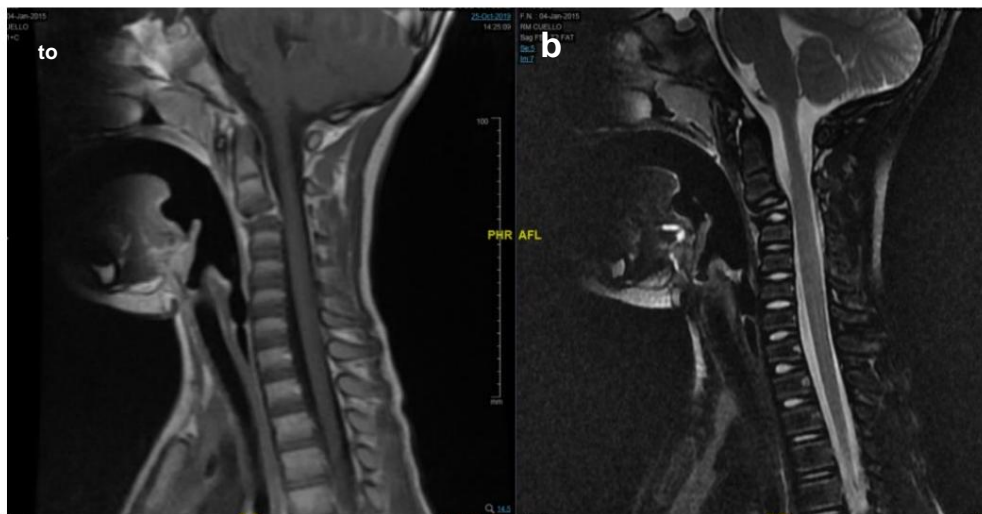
(a and b). T1 and T2-weighted MRI of the cervical spine, sagittal slices, showing flattening of the C3 vertebral body.
